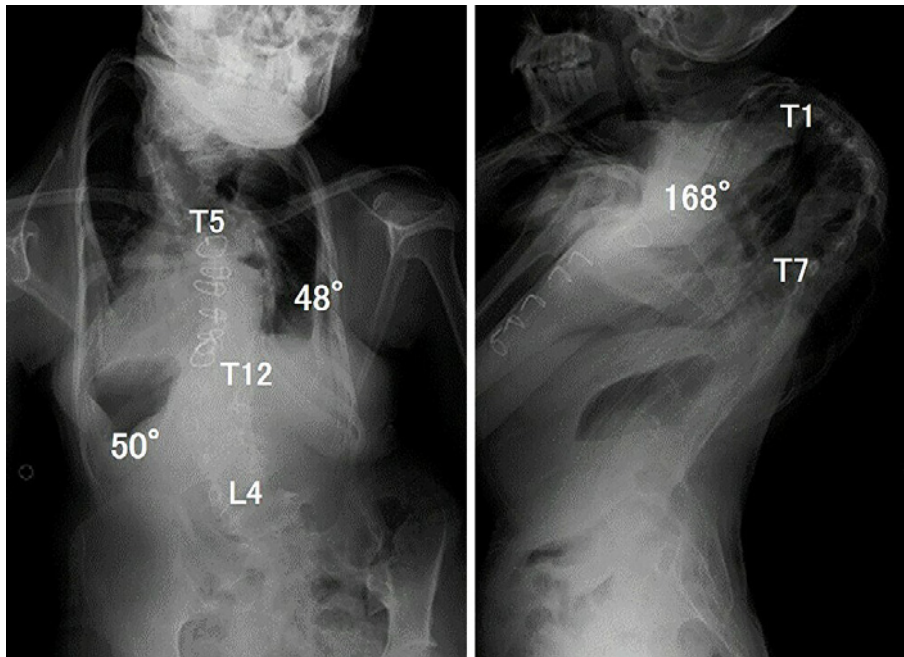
Radiographs before final correction and fusion surgery.
